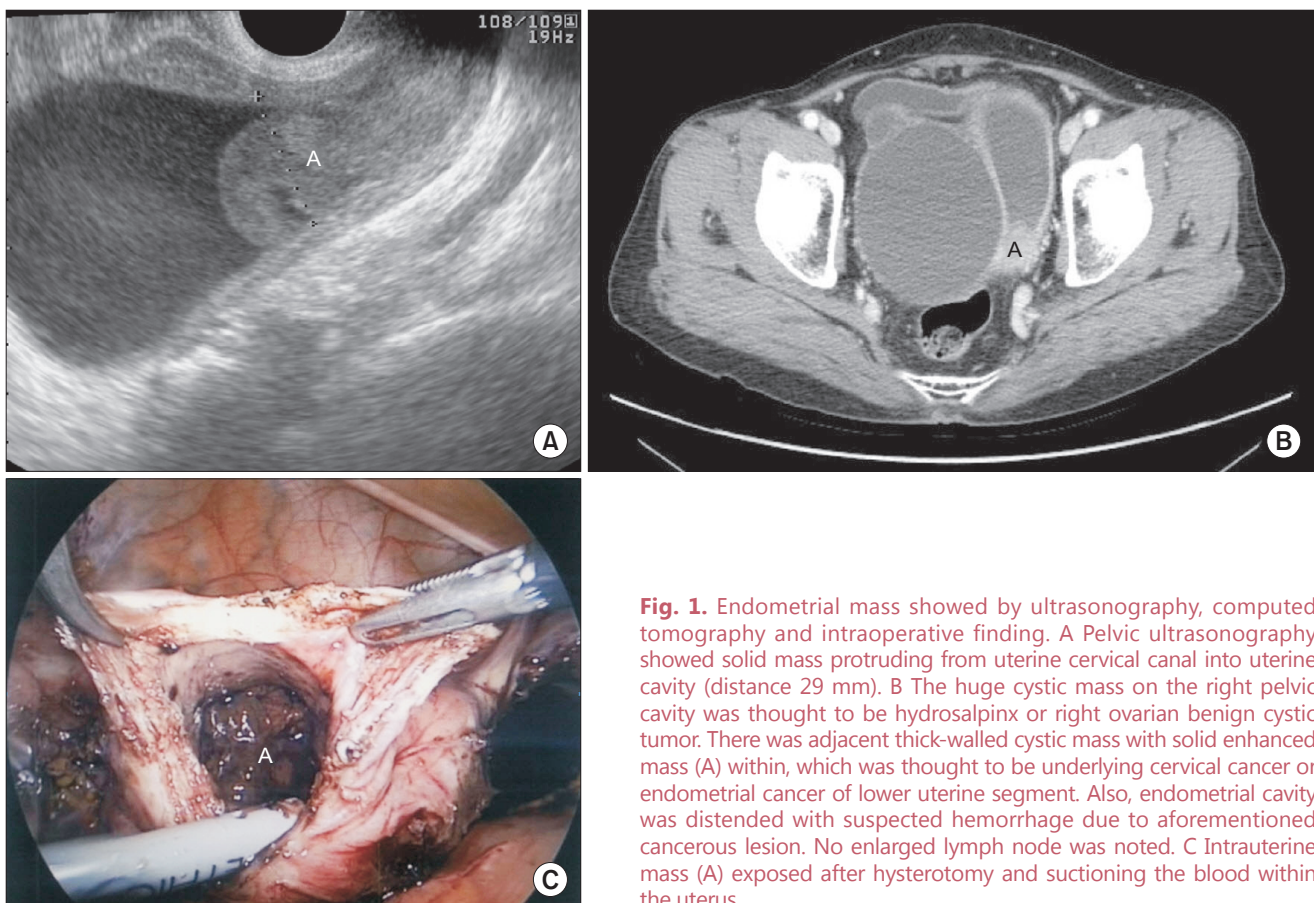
Endometrial mass showed by ultrasonography, computed tomography and intraoperative finding. A Pelvic ultrasonography showed solid mass protruding from uterine cervical canal into uterine cavity (distance 29 mm). B The huge cystic mass on the right pelvic cavity was thought to be hydrosalpinx or right ovarian benign cystic tumor. There was adjacent thick-walled cystic mass with solid enhanced mass (A) within, which was thought to be underlying cervical cancer or endometrial cancer of lower uterine segment. Also, endometrial cavity was distended with suspected hemorrhage due to aforementioned cancerous lesion. No enlarged lymph node was noted. C Intrauterine mass (A) exposed after hysterotomy and suctioning the blood within the uterus.
